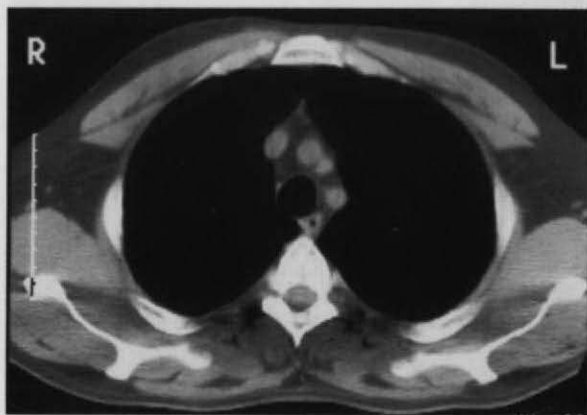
CT scan above the level of the aortic arch. Viewed from below, the oesophagus with a rather small round lumen is seen in front of the vertebral column, and the round translucency in front of the oesophagus is the trachea. The four opacities adjacent to the trachea are, from the right side of the body to the left, the superior vena cava, brachiocephalic trunk, left common carotid artery and left subclavian artery.
